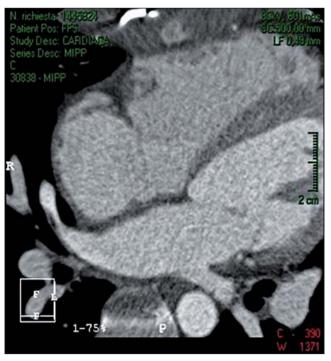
MRI transverse section view of the cardiac chambers.
